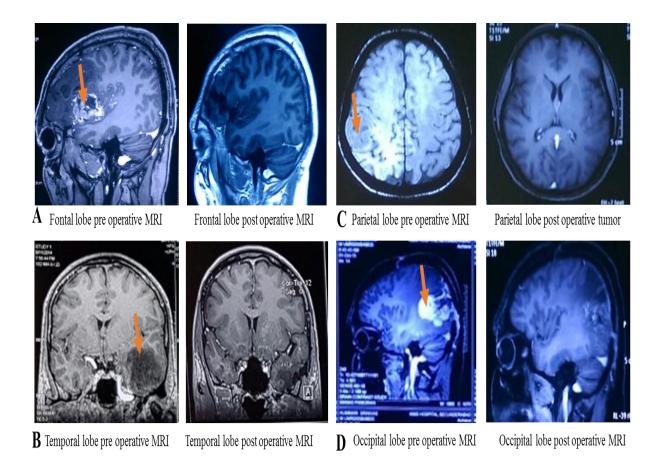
Representative images showing MRI imaging based categorization of tumor location: pre and post-operative MRI images of tumor located at A: frontal lobe, B: temporal lobe, C: parietal lobe, D: occipital lobe. Visible tumor has been marked by an arrow.
